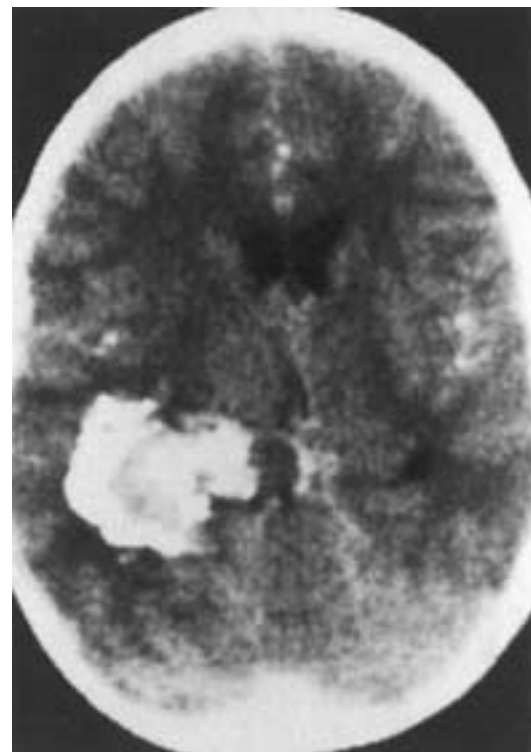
Oligodendroglioma. Axial CT image after enhancement shows a dense (calcified) right temporal lobe-thalamic mass.
